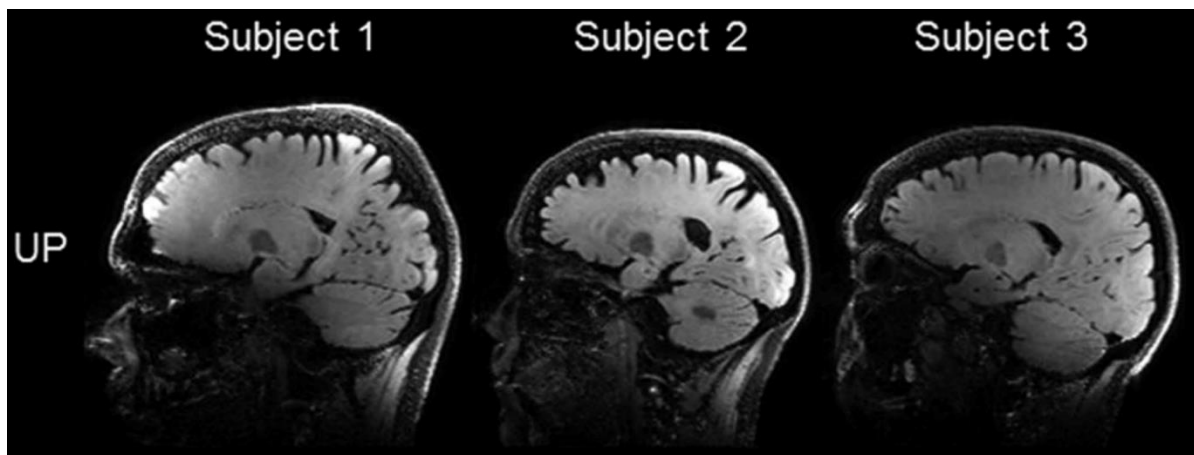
Sagittal image of a FLAIR-SPACE sequence acquired with an UP at 7T. The presented subjects were not contained in the design database of that UP. Reprinted from Gras et al. (17) with permission of John Wiley & Son, Inc.
